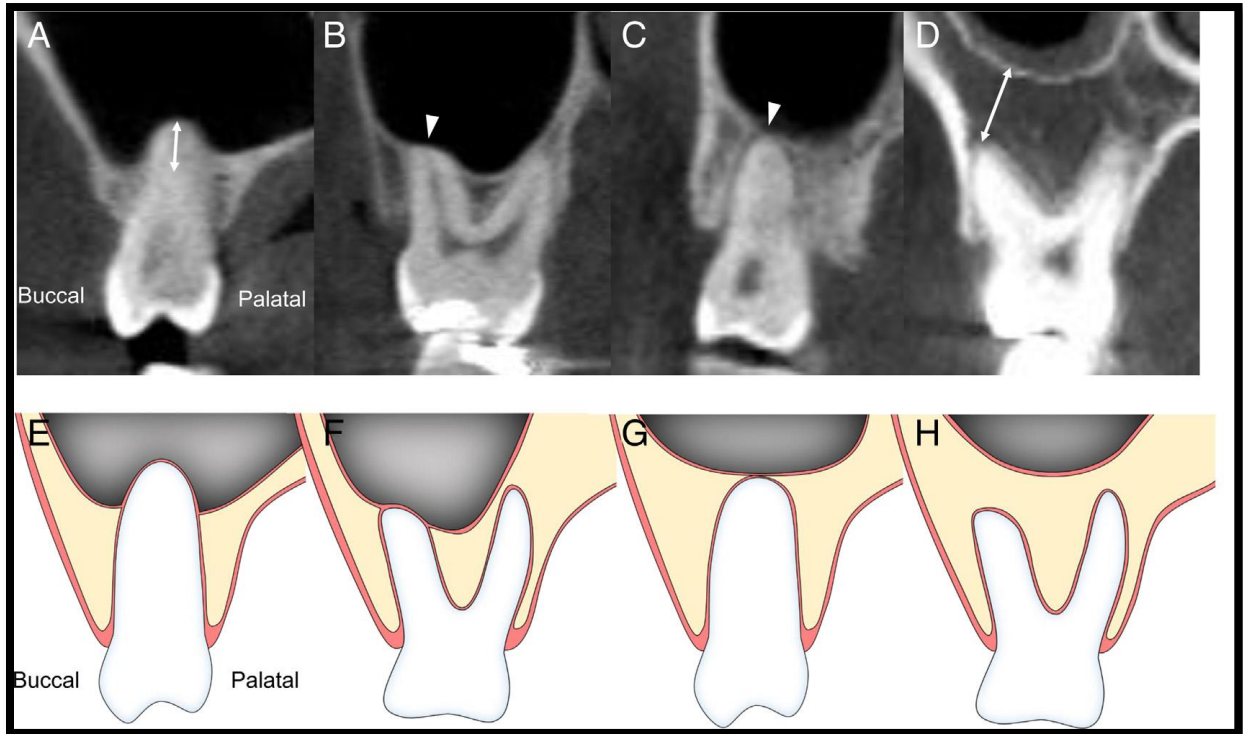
Maxillary CBCT images for the classification of the vertical relationship between the root apex of the maxillary posterior teeth and the MSF.
